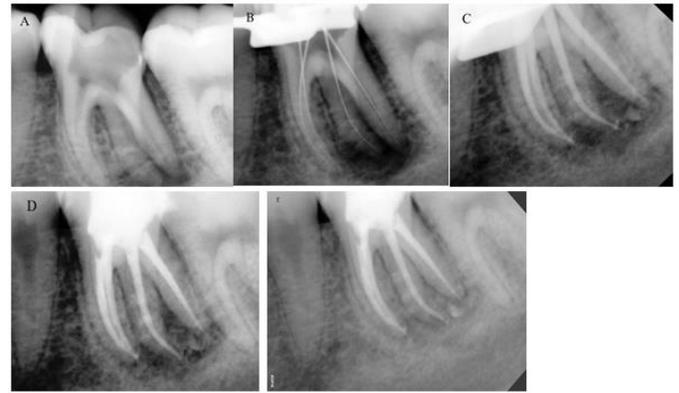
(A) Preoperative radiograph of 46 depicting the additional distal root and possibility of RE. (B) Working length radiograph of 46 revealing the existence of RE. (C) Master cone radiograph of 46. (D) Post obturation radiograph of 46 showing the RE. (E) 6 month follow up radiograph.
